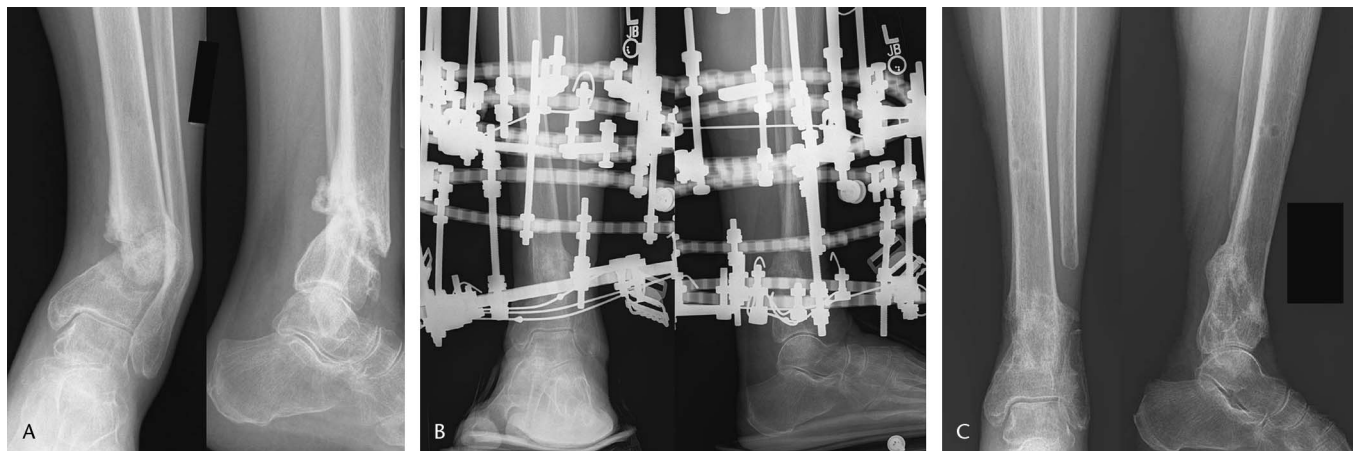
A, Presenting anteroposterior and lateral radiographs of an 80-year-old woman (patient 21) with type 2 diabetes mellitus who was referred 17 months following a closed distal tibia fracture treated at an outside facility with external fixation. The radiographs demonstrate a nonunion with an oblique plane angular deformity, which was not reducible using manual traction or reduction maneuvers. B, Radiographs 3 months following application of the Ilizarov external fixator show correction of the deformity and compression being applied (note bending of the wires). C, Final radiographic result at 32 months following application of the Ilizarov external fixator and 23 months following removal of the Ilizarov external fixator (total time in Ilizarov external fixator was 9 months) shows anatomic alignment with solid bony union. Partial fibulectomy was performed to facilitate Ilizarov gradual compression across the tibial nonunion site.
